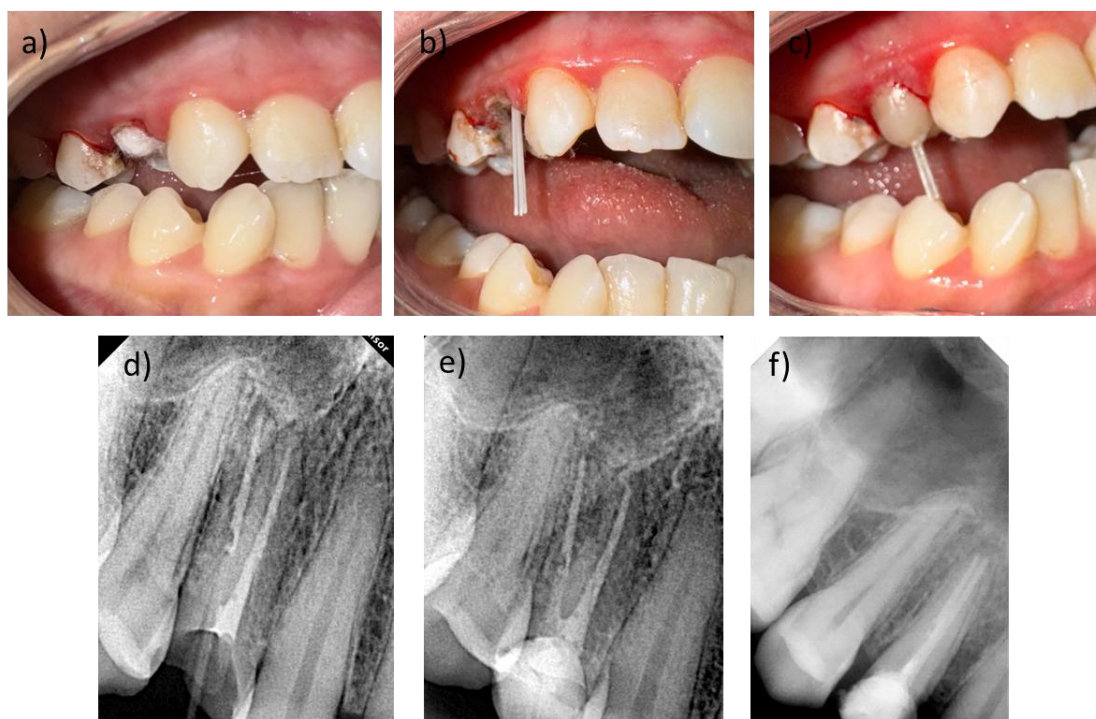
Visual of case 2, a) Initial intraoral view, b) Bundle post intraoral view, c) Core structure intraoral view, d) Bundle post control radiograph, e) Post-core restoration radiograph, f) 3-months follow-up radiograph
